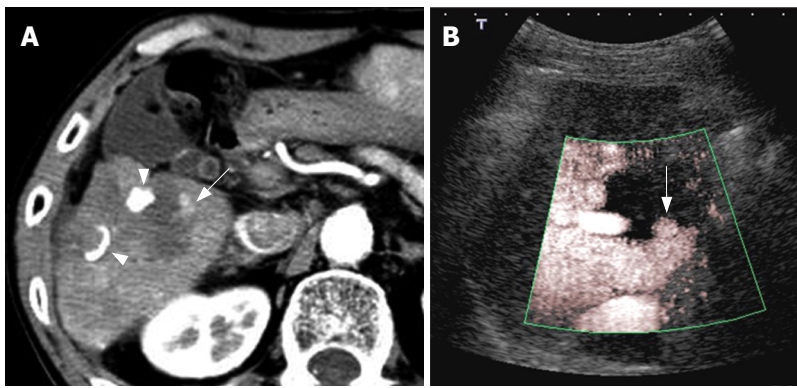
Assessment of therapeutic response after PEI for HCC. A: Contrast-enhanced CT with dynamic study; B: Contrast-enhanced US (Advanced Dynamic Flow with Levovist). Contrast-enhanced CT showed enhancement appearance which needed additional treatment within the treated area (arrow), and contrast-enhanced US could demonstrate a similar finding. Arrow heads: Lipiodol.
